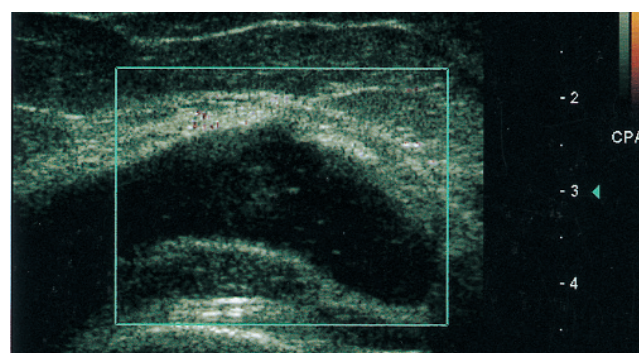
Osteoarthritis of knee joint (79-year-old woman): suprapatellar transverse scan (standard scan⁵) lateral recessus showing effusion with no power Doppler signal.
